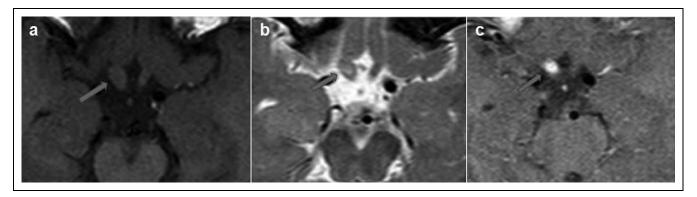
(A) TI-weighted magnetic resonance imaging (MRI) shows a hypointense mass lesion in the region of the right prechiasmatic optic nerve. (B) The lesion is slightly hyperintense on T2-weighted images. (C) Note that different from the first, this lesion demonstrates global enhancement following contrast administration.
